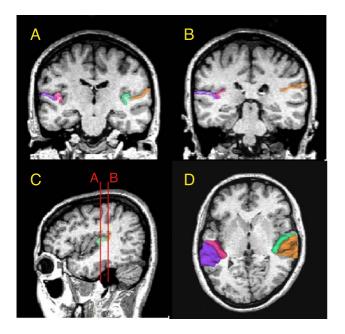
(Panels A and B) Delineation of Heschl's gyrus and planum temporale in a coronal slice in rostral and caudal part of regions of interest, respectively, based on MRI data of a control subject. The gray matter of Heschl's gyrus is labeled green on subject left and wine-red on subject right. The gray matter of planum temporale is orange on subject left and violet on subject right. (C) Sagittal view of the Heschl's gyrus and planum temporale in the left hemisphere. The coronal lines A and B correspond to the planes of panels A and B, respectively. (D) Three-dimensional reconstruction of Heschl's gyrus and planum temporale gray matter superimposed on the axial plane. Each region is labeled using the same color as that in panels A, B and C.
